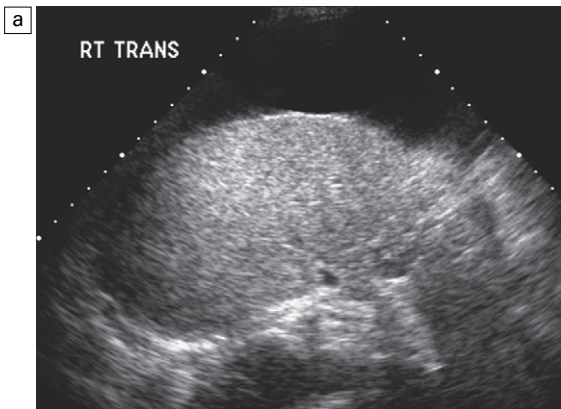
(a) Transverse image of the liver in a patient with severe cirrhosis. The liver is small, nodular and very echogenic. (b) Spectral Doppler tracing of the middle hepatic vein within the liver. Patency of the vessel is confirmed by colour Doppler but flow is markedly compromised by compression of this vessel. There is complete absence of periodicity and a relatively slow velocity.
